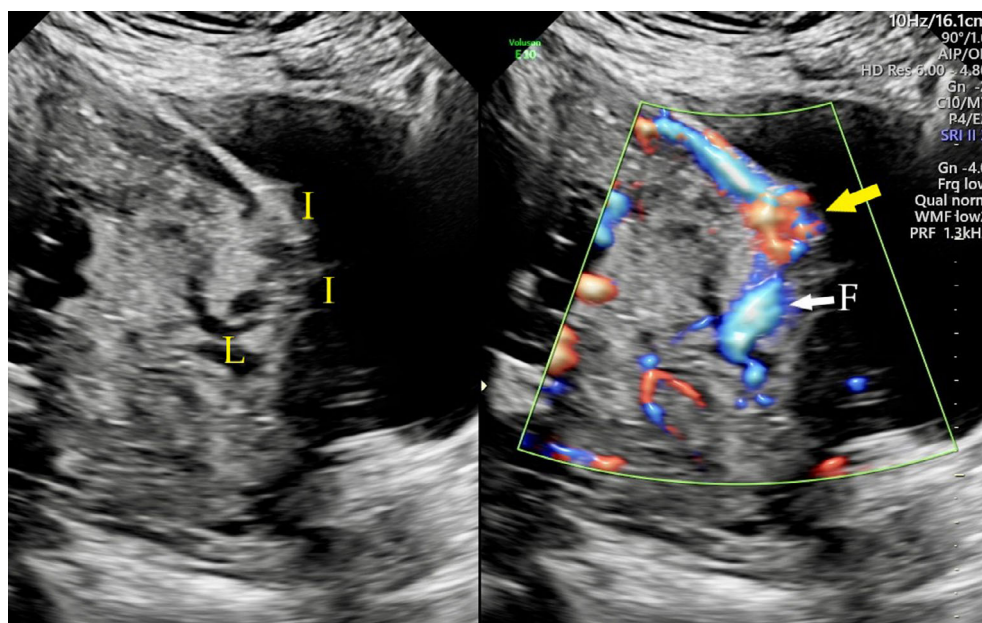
Bladder wall interruption ‘equals sign’ (I), bridging vessels when colour Doppler applied (yellow arrow), lacunae (L) and feeder vessels (thin arrow & F) in a case of FIGO Grade 3a (percreta). A fuller bladder would make the placental bulge and loss of clear zone more pronounced.
